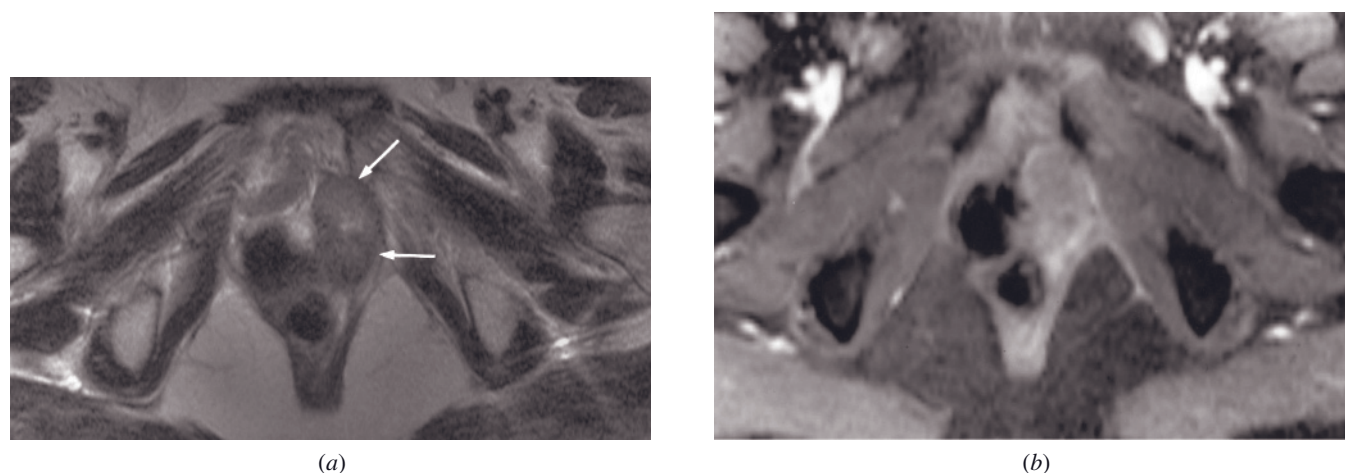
Recurrent urethral cancer. Transverse T2-weighted ETSE (*a*) and gadolinium-enhanced fat-suppressed SGE (*b*) images in a patient who underwent anterior pelvic exenteration for urethral cancer show an irregular left-sided mass (arrows, *a*) with heterogeneous enhancement (*b*) consistent with local recurrence.
